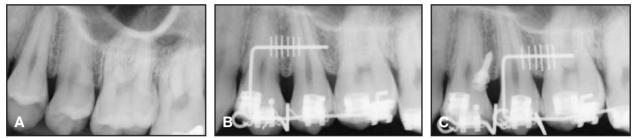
Case 2. A. Narrow space between roots of upper premolars. B. Radiograph taken with stent in place, showing interradicular space of less than 3mm. C. Miniscrew inserted in space between roots, with second stent for placement of miniscrew between second premolar and first molar.
